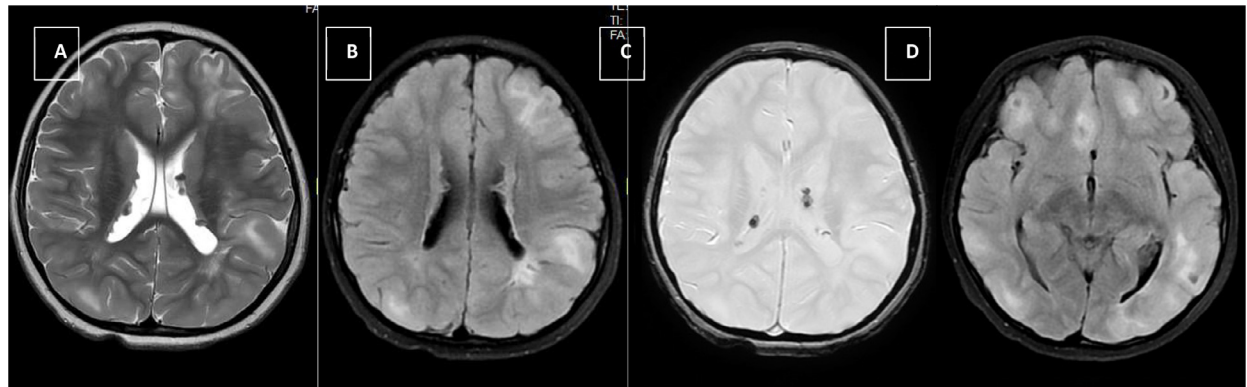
Gd-DTPA-enhanced brain MRI. (A, B, and C) Multiple subependymal nodules (SEN) at subependymal layers protruding into the adjacent ventricles, that were hypointense at T2, hyperintense at T2 Flair, and hypointense at SWI (susceptibility weighted imaging) due to calcification. (D) Multiple cortical tubers presented as focal white matter hyperintensities on T2 and hypointense at the central region, surrounded by a hyperintense rim on FLAIR, spreading at the frontal, temporal, and occipital regions bilaterally.
